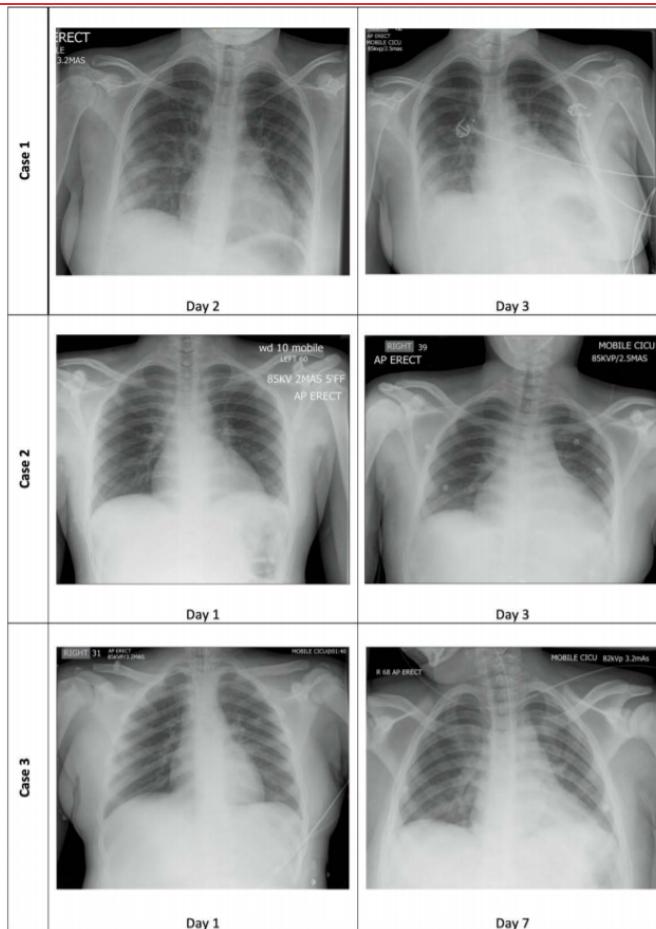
Chest radiographs of all three patients according to day of admission
